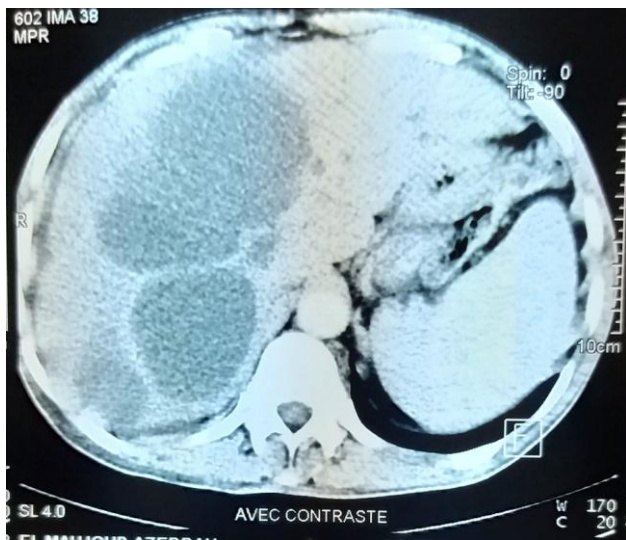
Abdominal CT scan showing metastases to the liver of primary pulmonary synovial sarcoma
